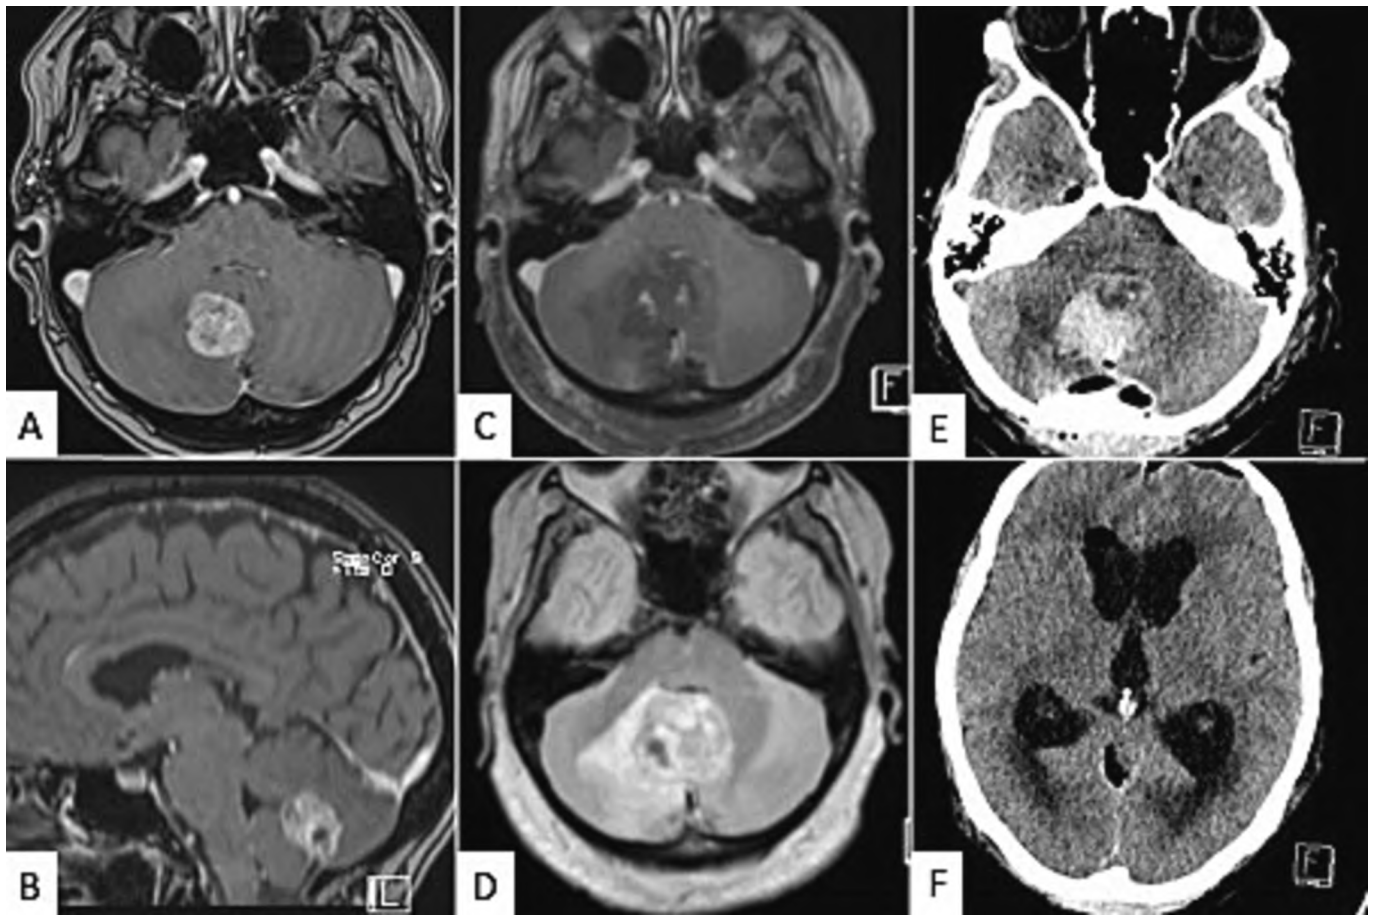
Preoperative 3T T1 + Gd Imaging (A, B) shows a contrast enhancing mass in the right cerebellar hemisphere. Postoperative resection control (C: T1 + Gd, D: FLAIR) confirms intracavitary hematoma and perifocal edema. After acute decline of vigilance, the emergency CT shows a compressive hematoma (E) with acute occlusive hydrocephalus (F).
